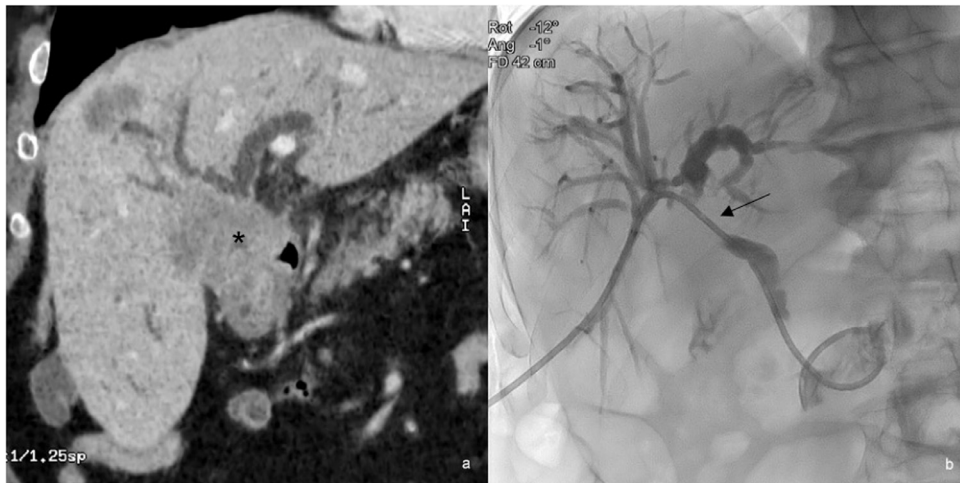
CT reconstruction in oblique coronal plane showing hepatic hilum metastasis (asterisk) causing biliary tree dilation and jaundice (a). Fluoroscopy shows an internal-external percutaneous biliary drainage and occlusion of the proximal segment of the biliary duct is evident as lack of contrast (b, black arrow).
